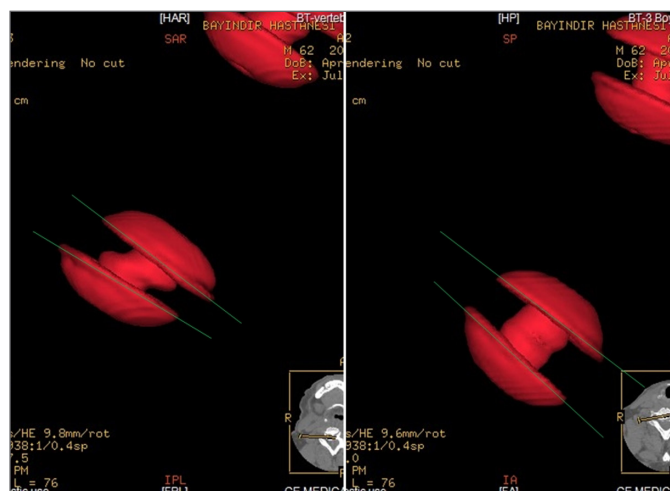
Sagittal 140° range of motion (ROM) of the prosthesis at the same level, which was defined as the angle formed by lines drawn at the edges of the prosthesis on the fine spiral CT section subtracted with the flexion and extension.
